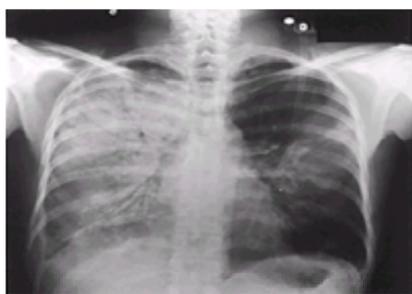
Marked alveolar infiltrates in the right lung with only a patchy area of infiltrate in left midlung. Significant hemoptysis in this patient was caused by systemic lupus erythematosus complicated by renal failure. Not all cases of diffuse alveolar hemorrhage show bilaterally symmetric chest roentgenologic abnormalities.
